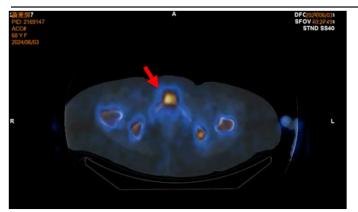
The enhancements of the hybrid SPECT-CT at the symphysis pubis confirmed the lesion. (Red arrow).
